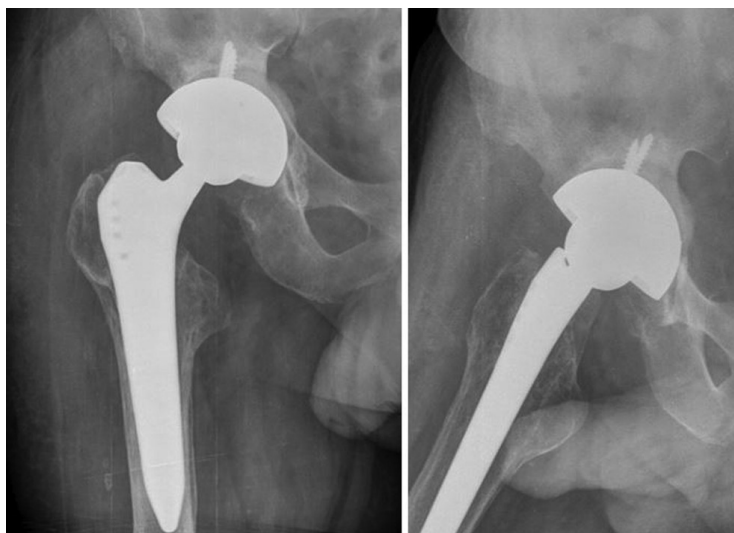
Radiographs of the right hip joint 6 months after the revision intervention
